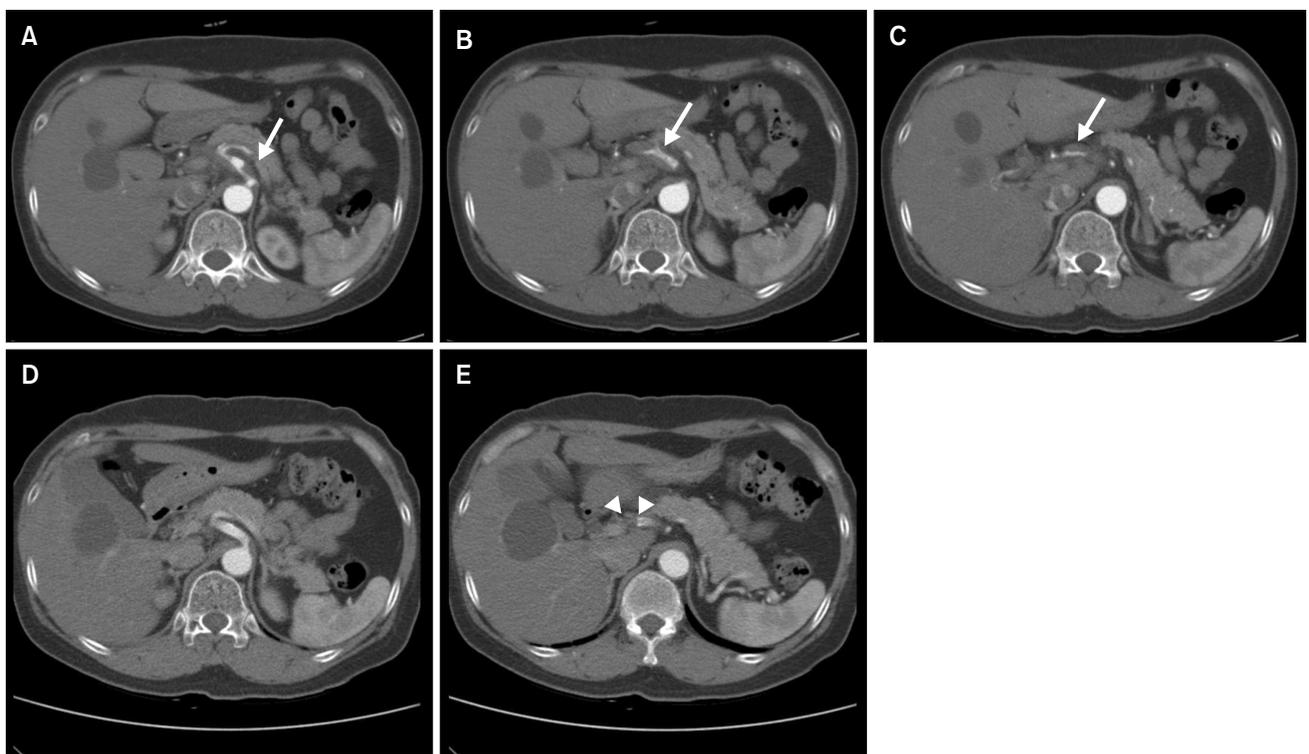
Representative computed tomography (CT) images of partial regression after endovascular intervention for spontaneous isolated dissection of the celiac artery. CT images before intervention (A–C) and 24 months after intervention (D, E). White arrows, dissection; arrowhead, partial regression.
